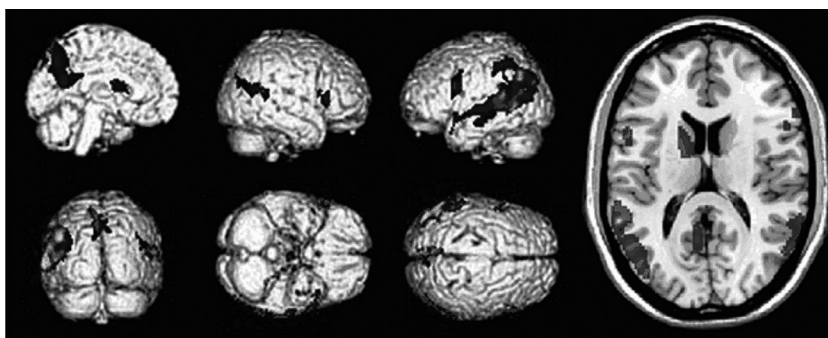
Areas of hypometabolism revealed by FDG-PET in the patient compared to healthy controls.
